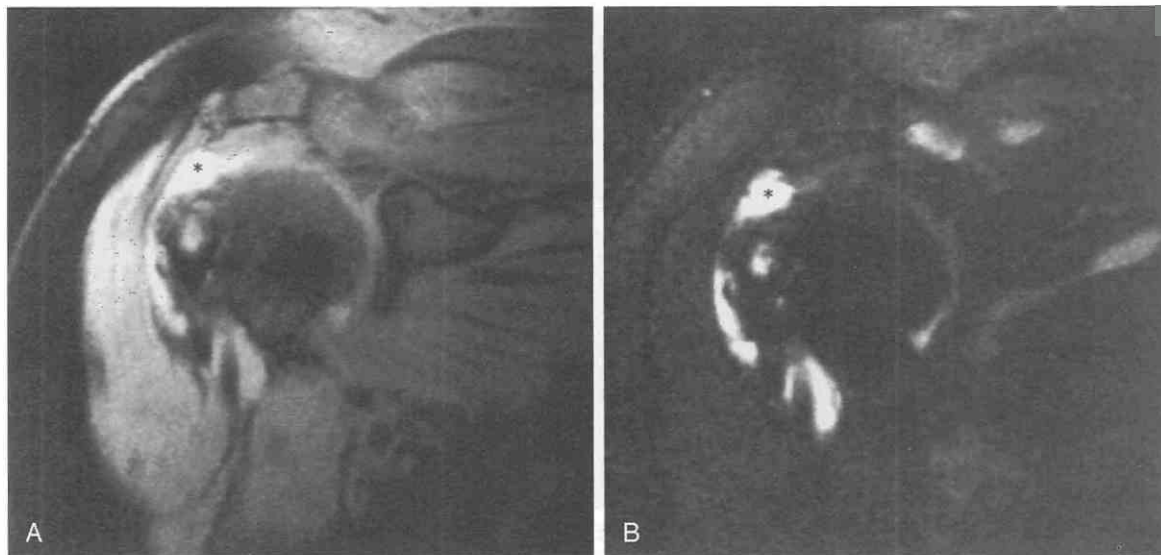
Fat-suppression technique. *A*, Proton-density-weighted (TR = 2000 msec, TE = 15 msec) coronal oblique image. *B*, T2-weighted (TR = 2000 msec, TE = 90 msec) coronal oblique image. Fat-suppression techniques may increase the conspicuity of a rotator cuff tear (*asterisks*) as well as that of a small cystlike defect in the humeral head, but less detail may be discernible elsewhere. (Courtesy of Thomas Hedrick, M.D., Houston.)
